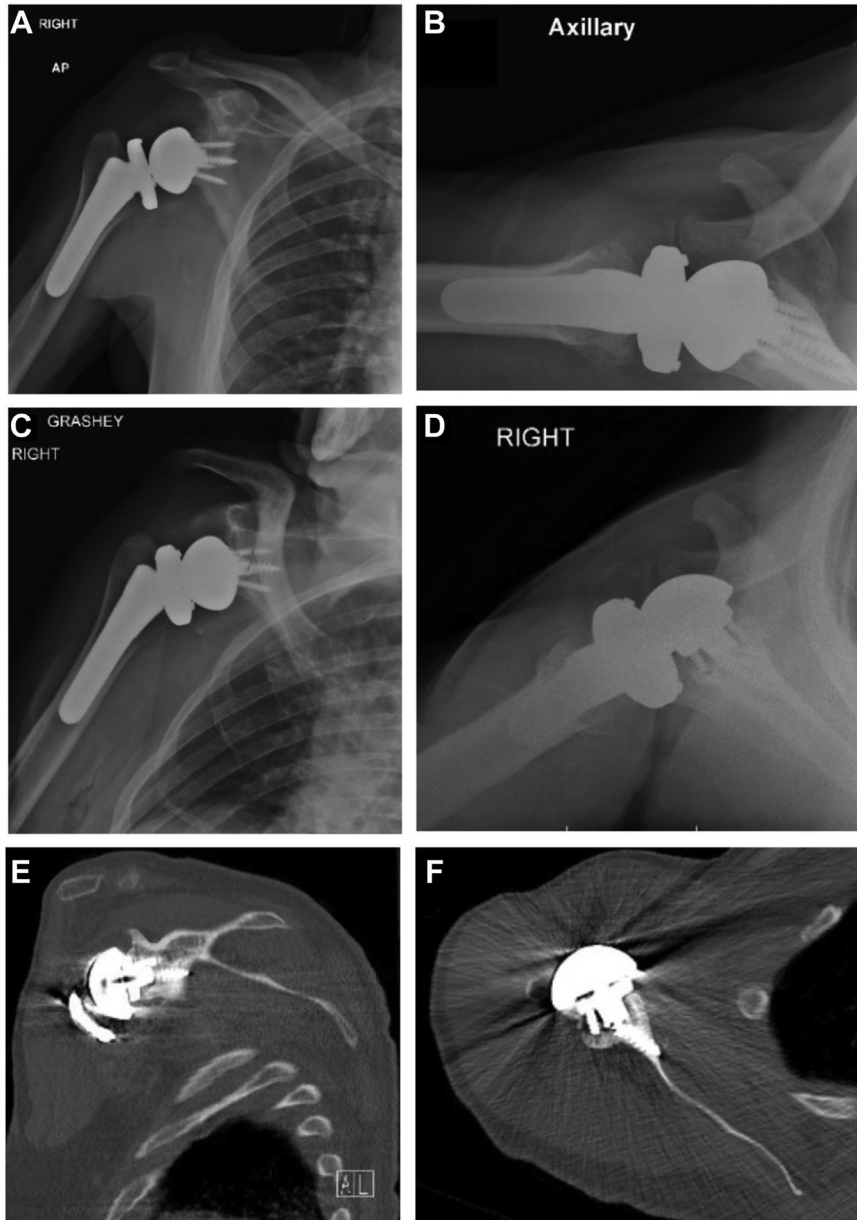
The patient in Fig. 1 initially underwent primary rTSA for right shoulder osteoarthritis with advanced posterior glenoid wear and calcification with partial tearing of the rotator cuff tendons. Primary implantation included 8 mm humeral head autograft for excessive posterior glenoid wear, 14 × 83 mm humeral stem, standard humeral tray with +3 retentive polyethylene insert, 25 mm glenosphere baseplate with 6.5 × 30 mm central non-locking screw and 4 peripheral locking screws (15, 20, 30, 35 mm), and a 41 mm standard offset glenosphere with Versa-Dial adapter set to C. Postoperatively at 6 months, anteroposterior (A) and axillary (B) radiographs showed intact glenoid and humeral implants. The patient had excellent ROM and strength. 4 years after primary rTSA, the patient presented with right shoulder pain after falling directly onto their shoulder 1 month prior to evaluation. (C) X-ray in the Grashey view of the right shoulder. (D) X-ray in the axillary view of the right shoulder. (E) Coronal CT of glenohumeral joint. (F) Axillary CT of glenohumeral joint. Imaging demonstrated failed right rTSA and right anterior glenoid fracture with failure of the glenoid baseplate. rTSA, reverse total shoulder arthroplasty; ROM, range of motion; CT, computed tomography.
